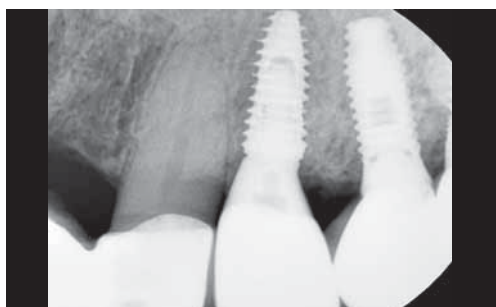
Periapical view of the final prosthesis.
